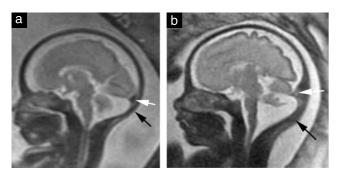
Demonstration of the torcular on fetal magnetic resonance imaging. (a) Fetus with Blake's pouch cyst with the torcular (white arrow) implanted close to the insertion of the neck muscles (black arrow). (b) Fetus with Dandy–Walker malformation with obvious upward displacement of the torcular (white arrow) compared with the neck muscles (black arrow). Notice also the greater size of the cisterna magna and the increased rotation of the cerebellar vermis compared with the fetus in (a).
